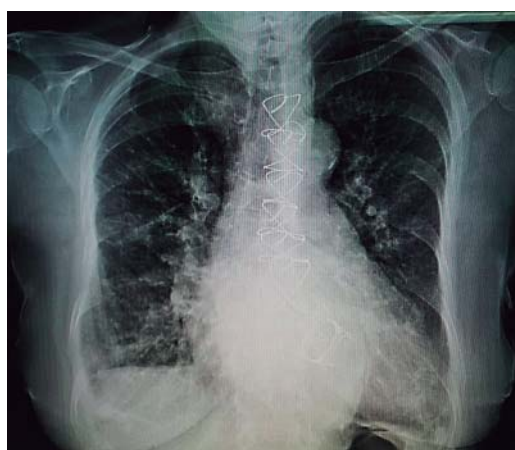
Chest X-ray in anteroposterior projection, right hemidiaphragmatic elevation, apparent cardiomegaly, with both costodiaphragmatic and cardiofrenic angles deleted on right hemidiaphragm, suggestive of pleural effusion of 25%, with images of valvular stents in mitral and aortic positions, with increased bilateral vascularity and prominent pulmonary cone.
